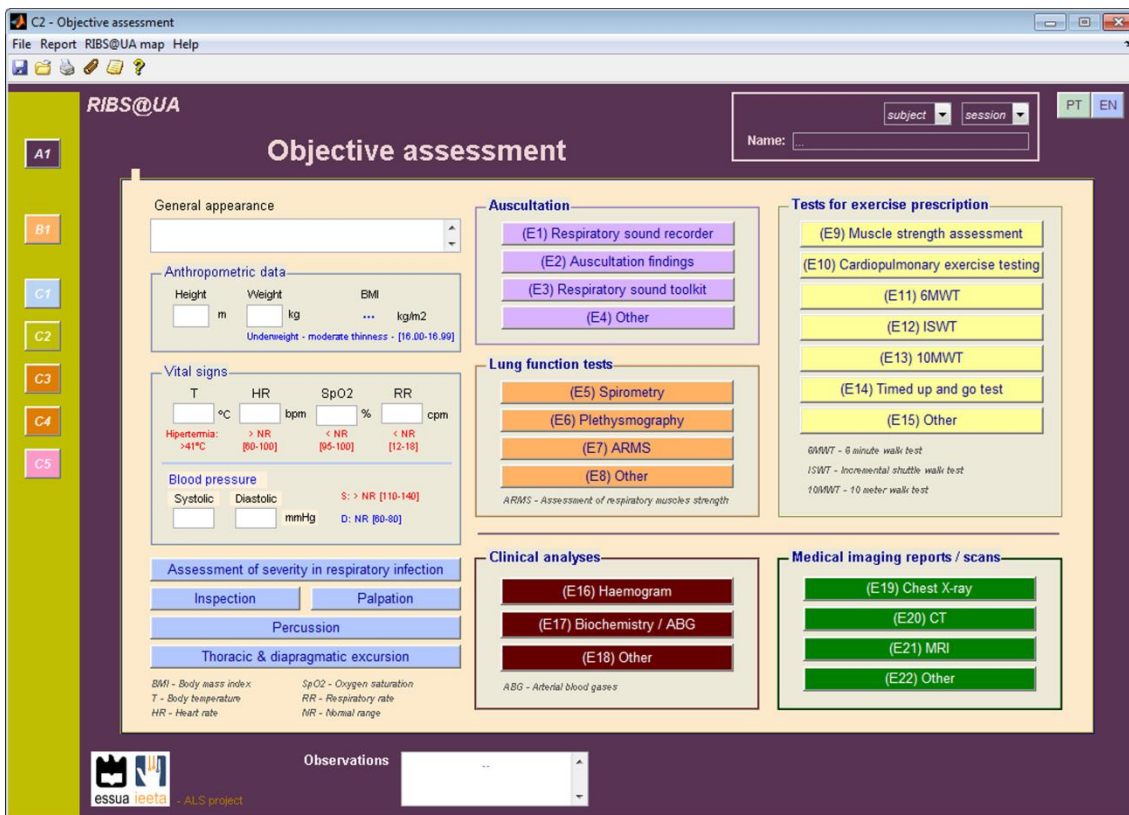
Window C2 - Objective assessment. *CT* - computerised tomography; *MRI* - Magnetic resonance imaging.
